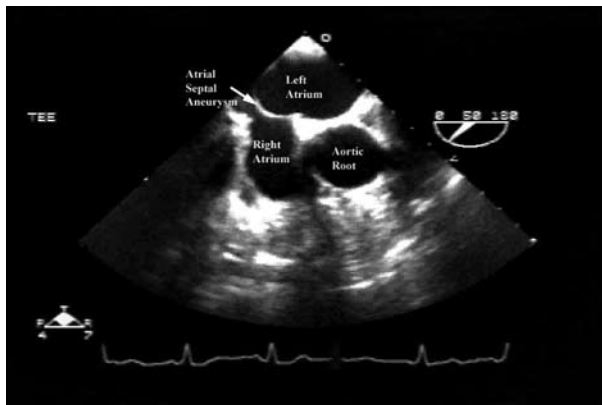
Transesophageal echocardiogram shows an atrial septal aneurysm (*arrow*) contracted into the right atrium (*left*) and expanded into the left atrium (*right*) during a cardiac cycle.
